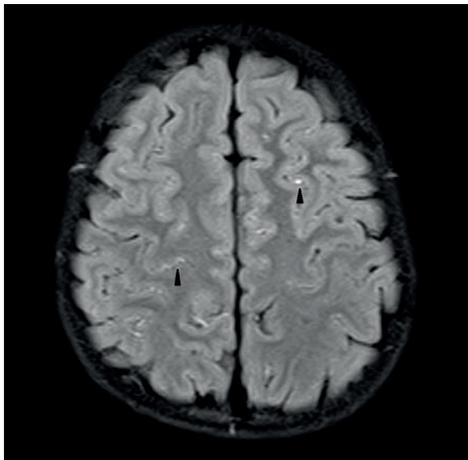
Axial FLAIR image shows high signal intensity at sulci called 'ivy sign' (black arrowheads) (Case 7).
